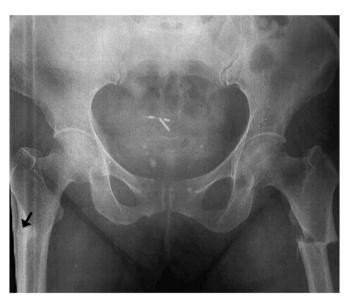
Plain radiograph showing a transverse infra-trochanteric fracture of the shaft of the left femur and a pseudo-fracture involving the lateral cortex of the shaft of the right femur (marked in black arrow).
